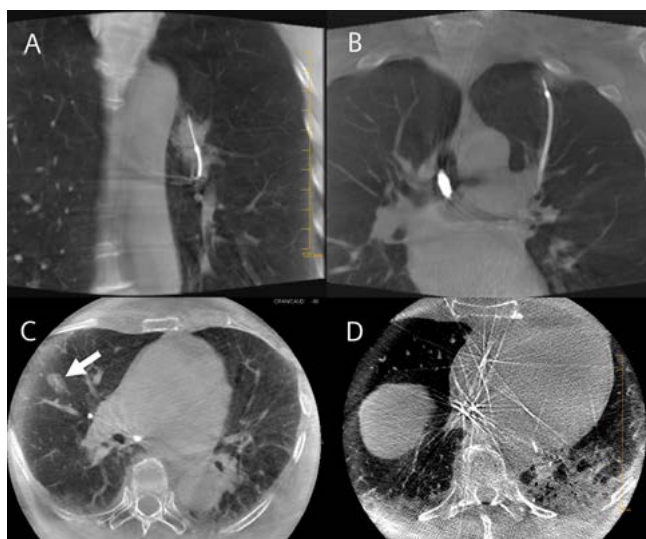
CBCT images of PLL and atelectasis using a fixed angiographic system. (A) solid lesion; (B) semi-solid lesion; (C) ground glass opacity (GGO) lesion, denoted by arrow; (D) dependent sublobar atelectasis. Images (A) and (B) also depict Tool-in-Lesion confirmation during PLL biopsy.
